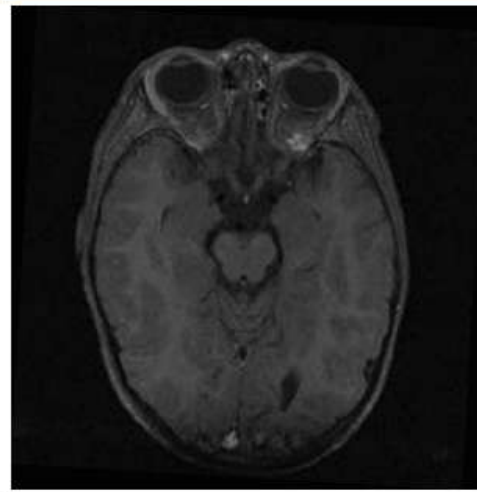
Cerebral magnetic resonance imaging showing a left retrobulbar heterogenic lesion (diameter: 15 × 14 × 11 mm), that shows enhancement after contrast.
